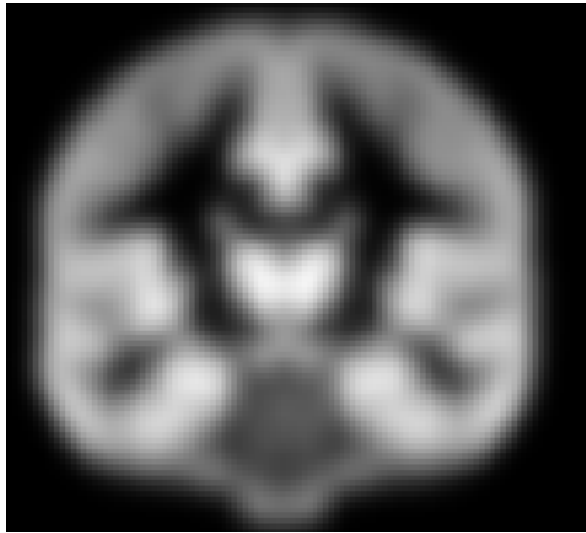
Classification of tissues in MRI slice into internal and external cerebral-spinal fluid (yellow and red labels), gray and white matter (blue and green labels).
